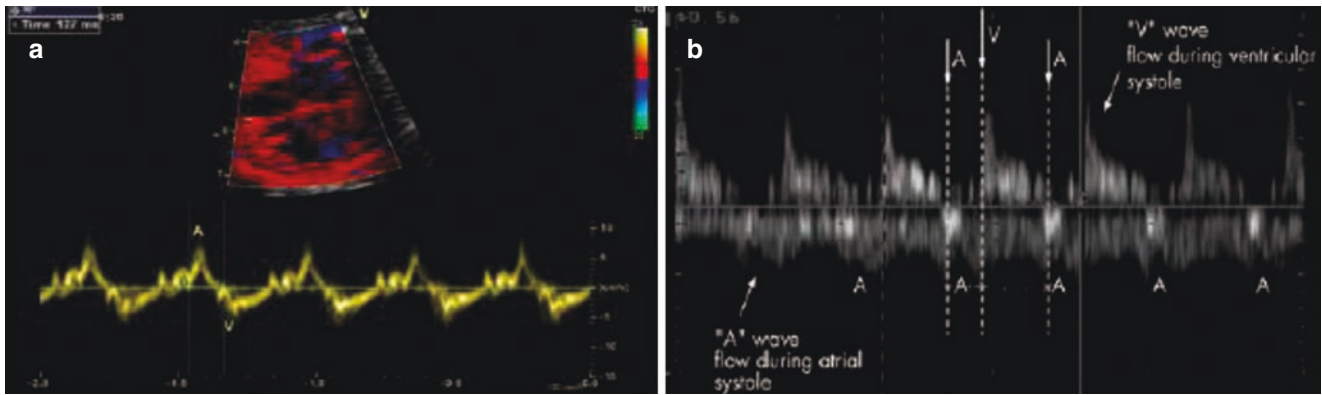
Evaluation of the PR interval (A-V interval in the figure) by the method of simultaneous spectrum Doppler A-V interval (a) and recording the spectrum of pulmonary artery and vein (b). References:
